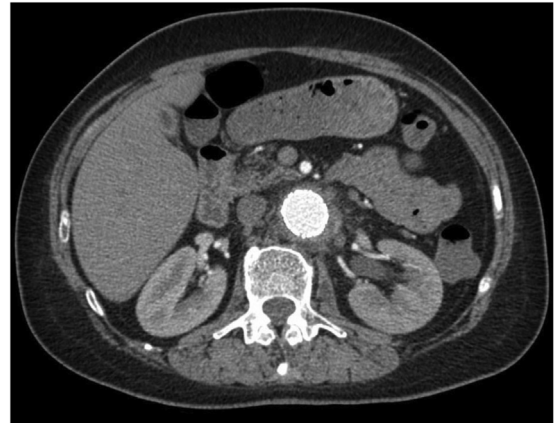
Axial reconstruction of computed tomography angiography (CTA) of patient B demonstrating inflammation in the periaortic space near the proximal endograft.
